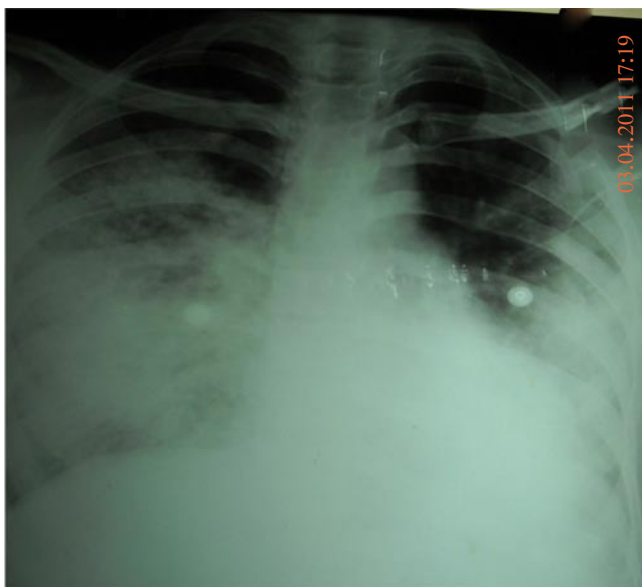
Chest X-ray showing bilateral non-homogenous opacities.
